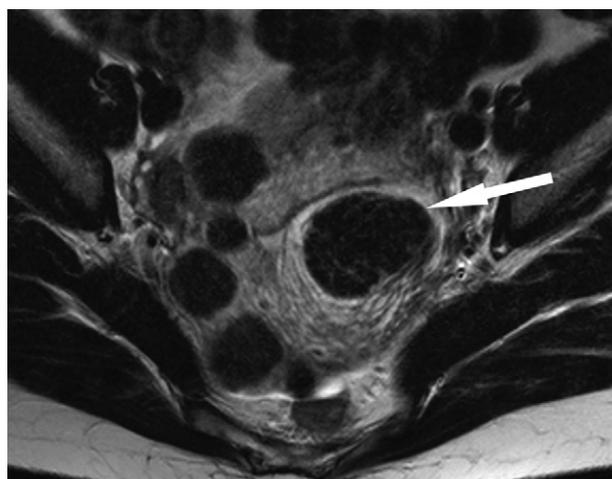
36-year-old woman with multiple uterine fibroids, complaining from menometrorrhagia with clotting. T2-weighted fast spin-echo MR image in the sagittal plane shows multiple intrauterine fibroids in association with a large, protruding subserosal fibroid (arrows). The subserosal fibroid was resected using laparoscopic myomectomy while the intrauterine fibroids were left in place and treated with uterine artery embolization.
